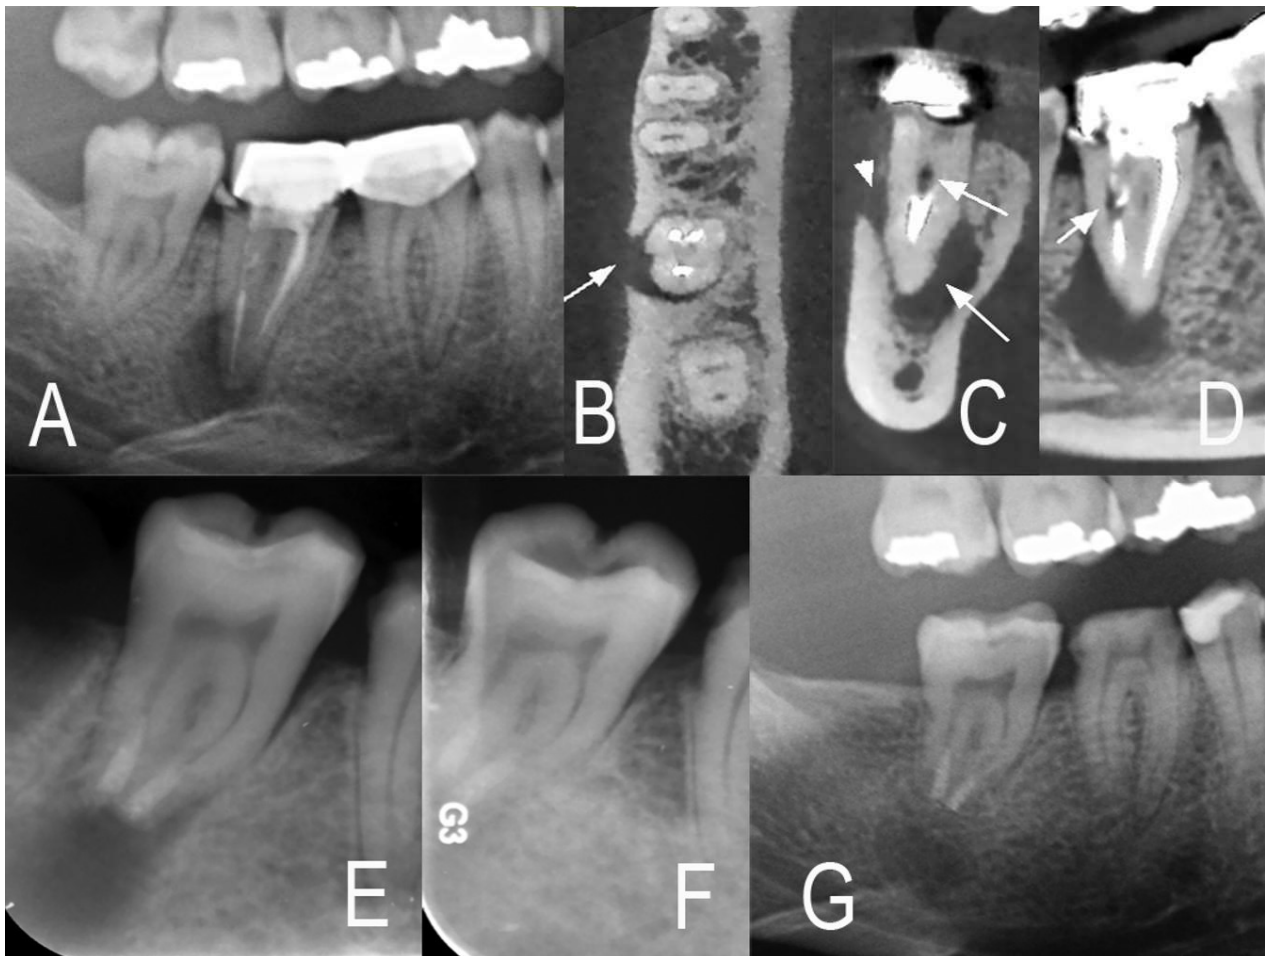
Radiographic Presentation of Autotransplantation Procedure (A) Orthopantomogram (OPG) image showing tooth 37 with a defective PFM crown, recurrent caries, poor root canal obturation, and a large endodontic lesion. (B-D) Cone-beam computed tomography (CBCT) scans, in axial/coronal/sagittal planes, demonstrating extensive bone destruction around tooth 37 and perforated buccal cortical bone. (E) Immediate postoperative radiograph confirming the successful tooth autotransplantation procedure. (F) Radiographic assessment at the 1-year recall, demonstrating successful healing of the endodontic lesion and proper integration of tooth 38. (G) Radiographic assessment at the 5-year recall, showing a normal periodontal ligament width and functional adaptation of the transplanted tooth within the occlusal scheme.
